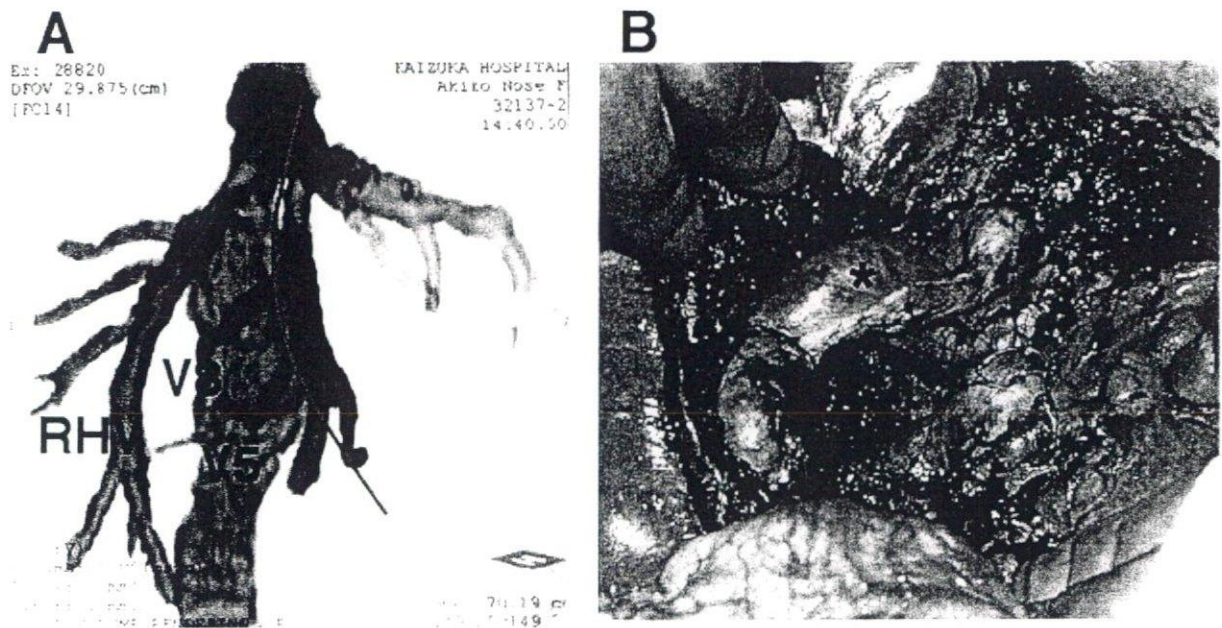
A, A 3D-CT image of the MHV and its tributaries (V5 and V8) and a transection line. B, The right lobe graft after reperfusion. *A reconstructed umbilical vein graft.
